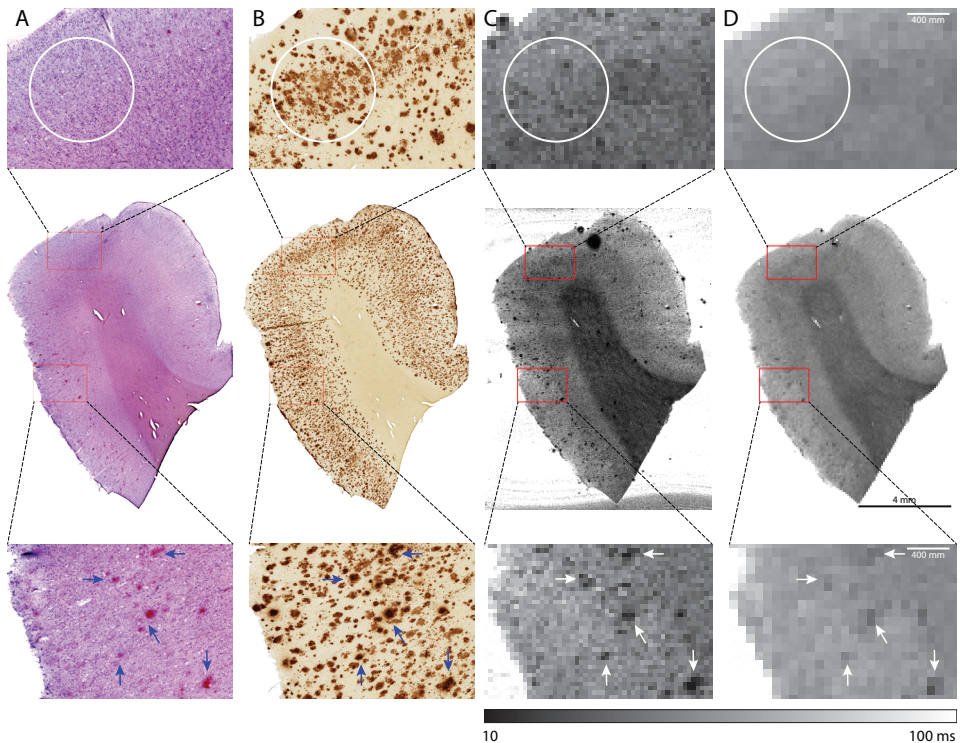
MRI characteristics of diffuse plaques
